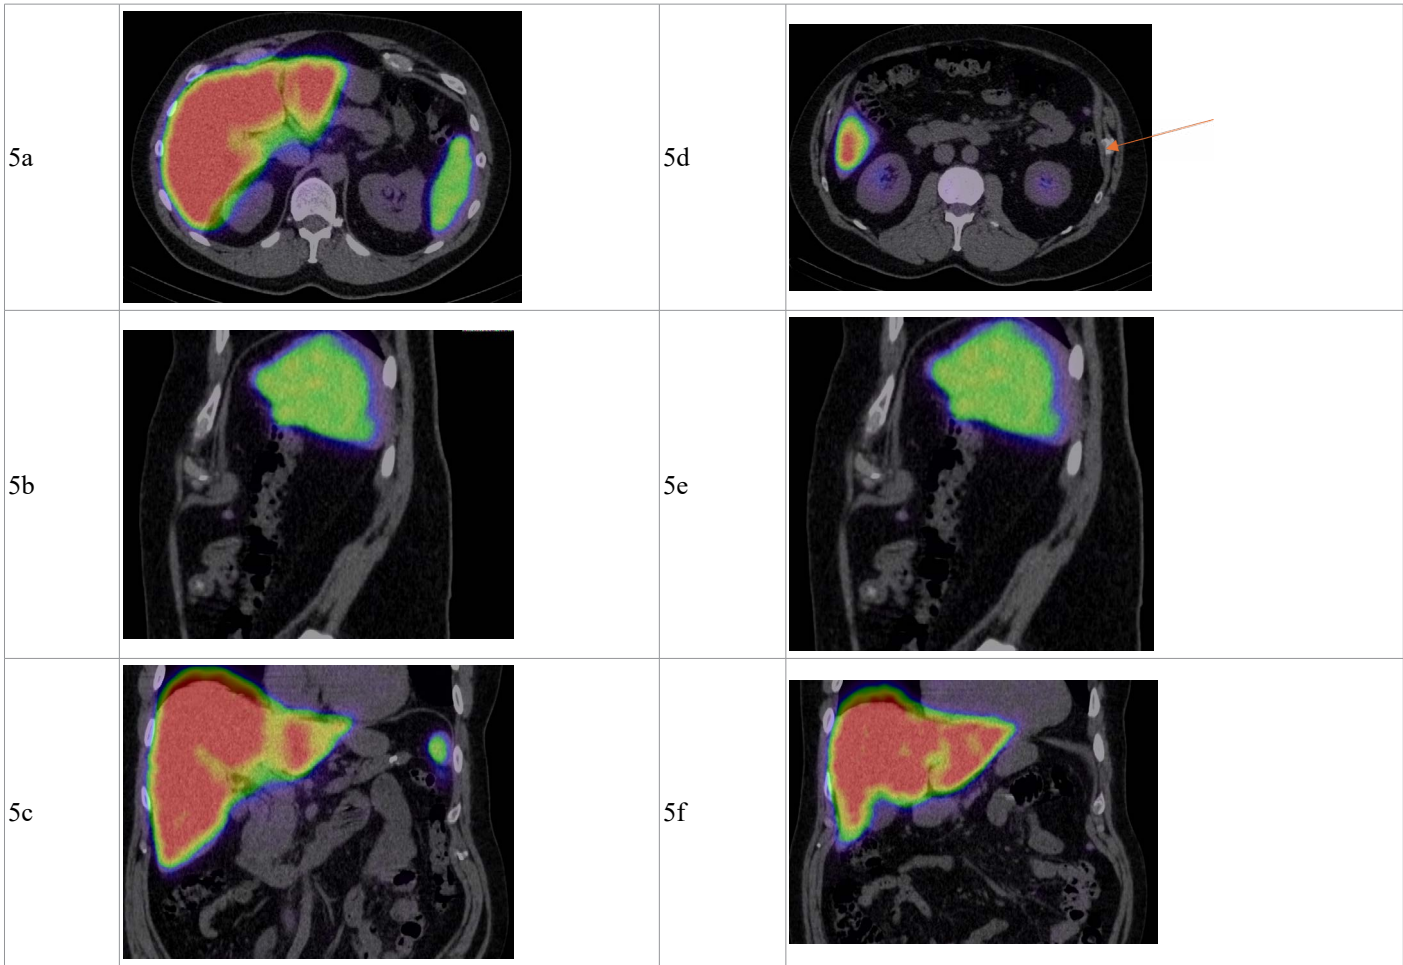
Tc-99m sulfur colloid liver–spleen scintigraphy demonstrating absence of uptake within a left upper quadrant peritoneal nodule prior to confirmatory Tc-99m heat-damaged red blood cell imaging
